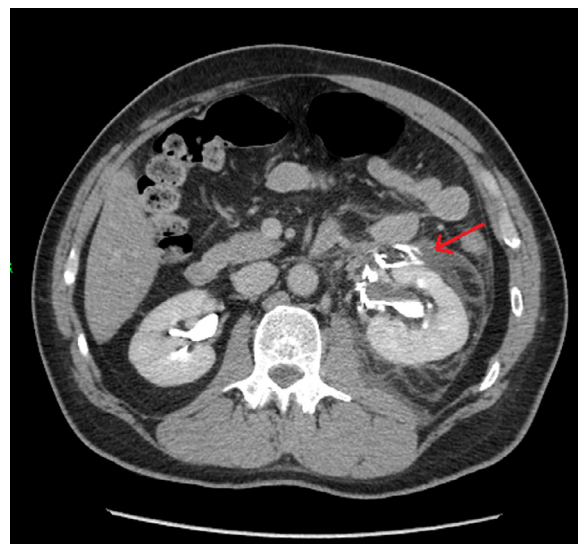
Contrast-enhanced CT in axial plane, after 8 minutes, showing, at the point indicated by the arrow, the iodinated urine leakage and the increasing density of fluid collection.
